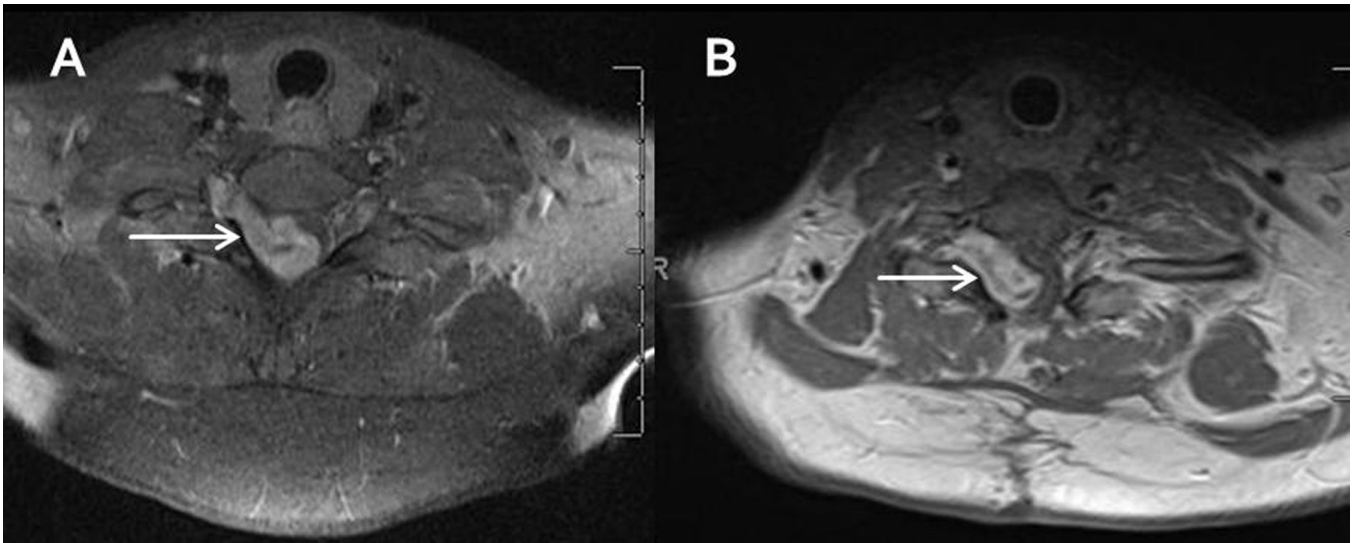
(A) Axial T1-weighted postcontrast MRI (July 2012) showing an extramedullary intradural mass at C7–T1 (arrow) extending through the neural foramina. (B) Axial T1-weighted postcontrast MRI (February 2014) showing the recurrent heterogeneously enhancing extramedullary intradural lesion expanding through the C7–T1 neural foramen.
